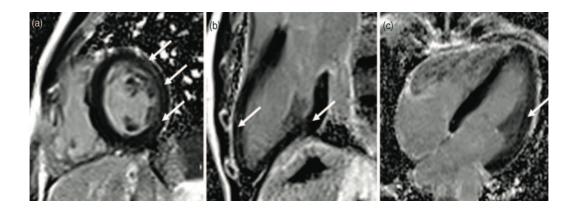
Cardiovascular magnetic resonance image of myocarditis in HIV. LGE image showing linear midwall fibrosis in the inferolateral and anterior walls in short-axis (a), vertical long-axis (b) and horizontal long-axis views (c).
